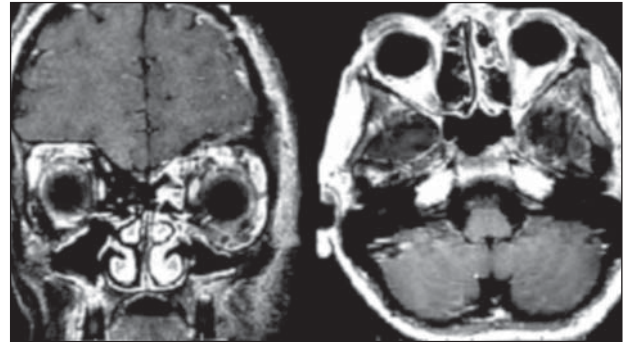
Coronal e axial T1 sequence of post-operative MRI, showing resection of the lesion.
